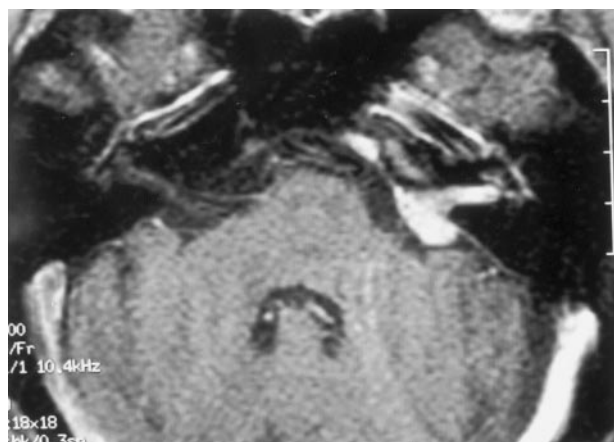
Case 3: 67-year-old woman with an intracanalicular meningioma. Contrast-enhanced axial T1-weighted MR image (600/9) shows an enhancing mass occupying the IAC and extending out to the cerebellopontine angle.
